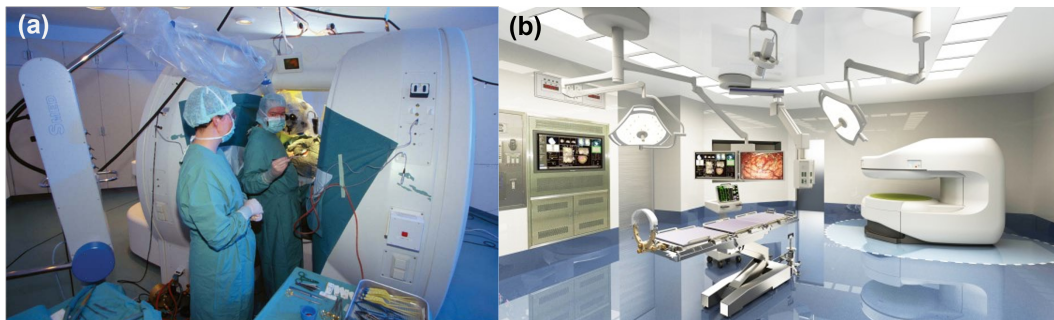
(a) Surgeons perform surgery in a GE Signa SP system. Image source: [7]. (b) Setup of the Hitachi intra-op MRI system integrating operating theatre and MR scanner in one room. Image source: [8].
